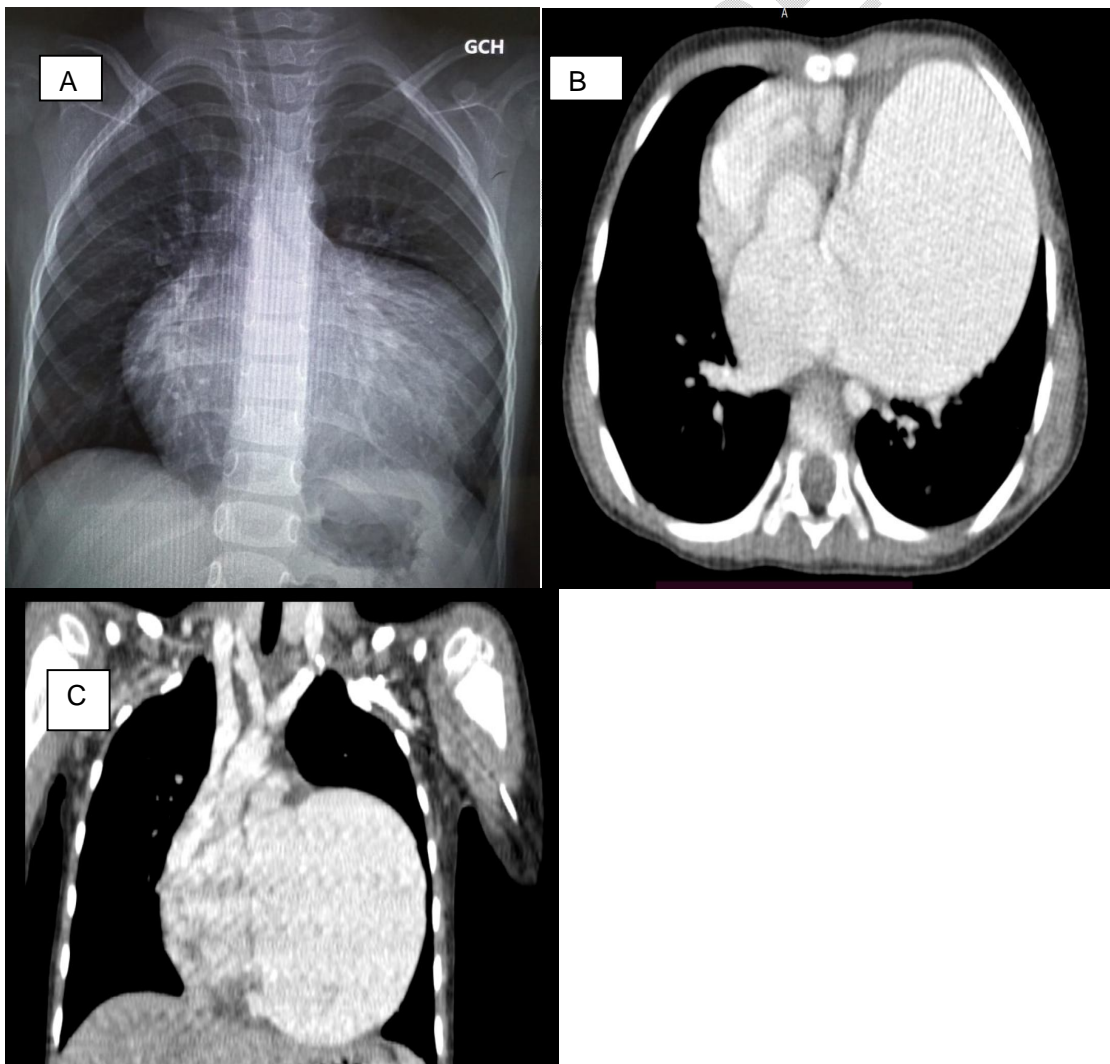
Cardiomegaly with a structure superimposed on the left ventricle (A). Chest CT scan showing a giant LAA measuring 80 x 87 x 72 mm(B)+(C).
